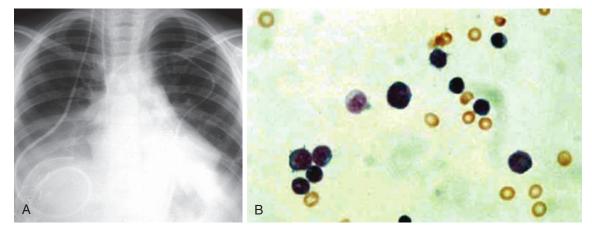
Malignant pleural effusions. A, This chest x-ray shows an abnormal collection of pleural fluid. If malignancy is suspected, the diagnosis can sometimes be made through analysis of the pleural fluid. B, Cytology of the pleural fluid obtained by thoracentesis demonstrates large cells, high nuclear-to-cytoplasmic ratios, and fine nuclear chromatin, all features of malignant disease.
